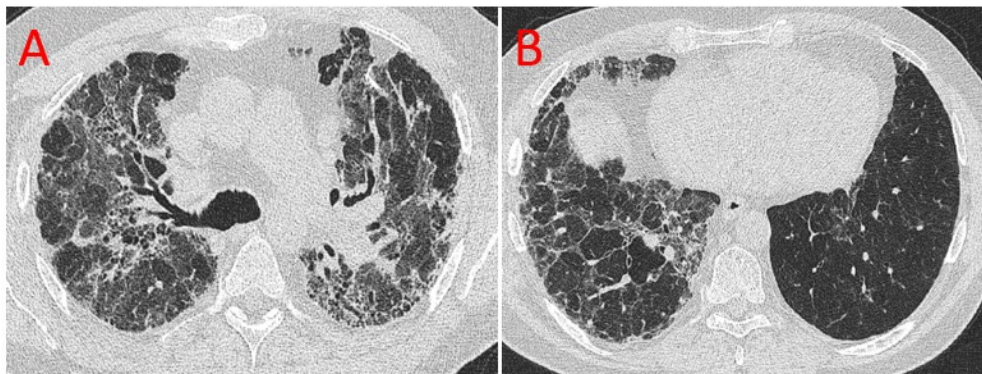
High resolution CT dicom's from a patient with Chronic hypersensitivity pneumonitis from the ILD-PH cohort.
